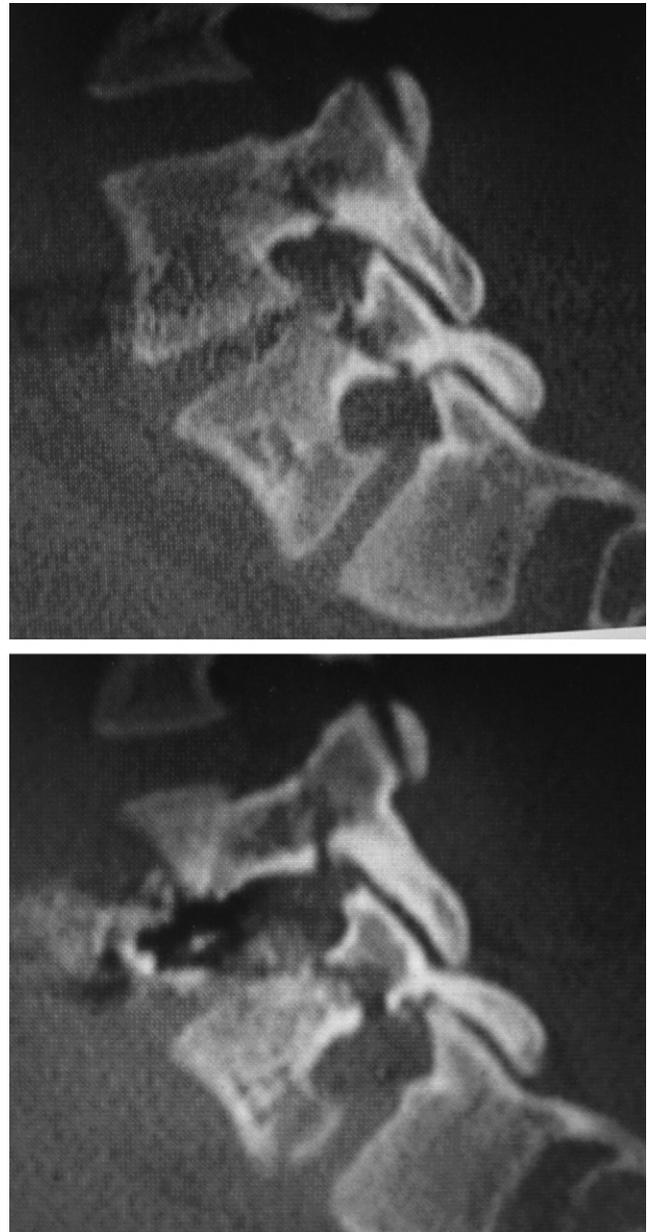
(Top) A sagittal reconstruction of the lumbar CT scan demonstrating the disrupted left L4 and L5 pedicles. (Bottom) A sagittal reconstruction of the lumbar CT scan demonstrating a right L4 inferior end plate fracture and right L4 and L5 pedicle fractures. CT, computerized tomography.
